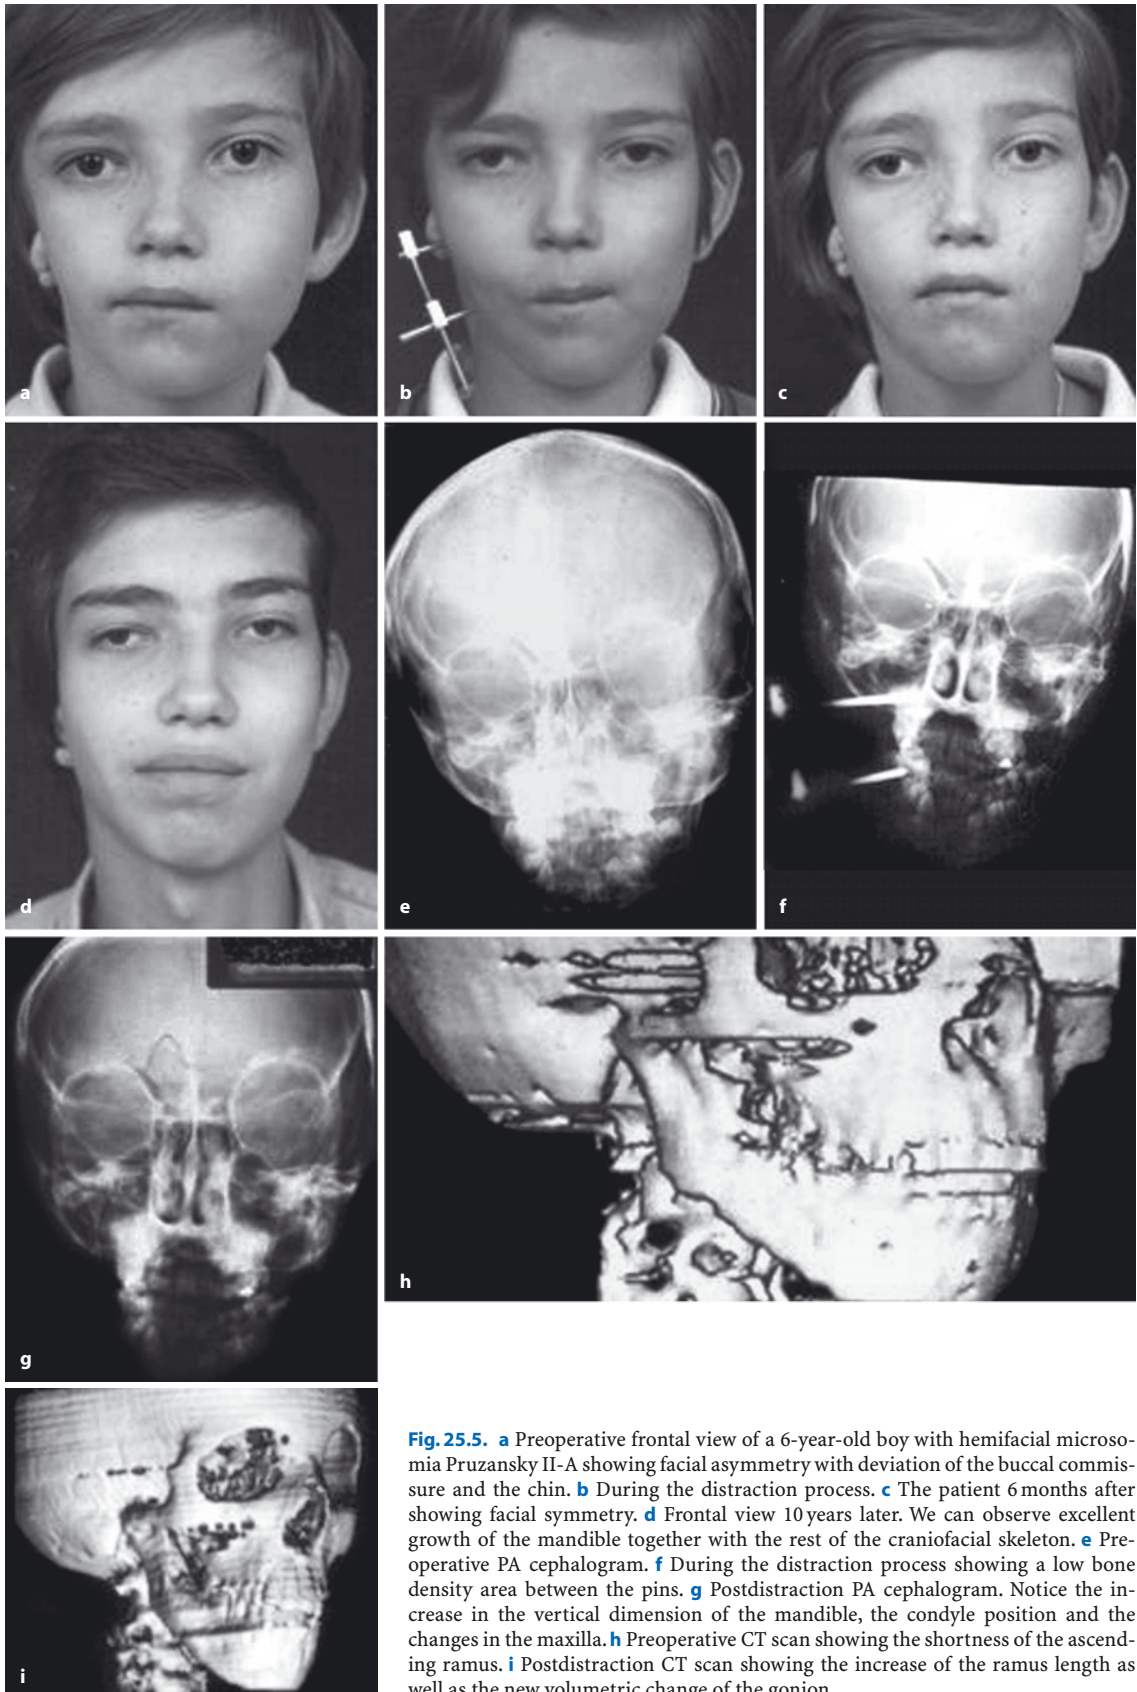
a Preoperative frontal view of a 6-year-old boy with hemifacial microsomia Pruzansky II-A showing facial asymmetry with deviation of the buccal commissure and the chin. b During the distraction process. c The patient 6 months after showing facial symmetry. d Frontal view 10 years later. We can observe excellent growth of the mandible together with the rest of the craniofacial skeleton. e Preoperative PA cephalogram. f During the distraction process showing a low bone density area between the pins. g Postdistraction PA cephalogram. Notice the increase in the vertical dimension of the mandible, the condyle position and the changes in the maxilla. h Preoperative CT scan showing the shortness of the ascending ramus. i Postdistraction CT scan showing the increase of the ramus length as well as the new volumetric change of the gonion
